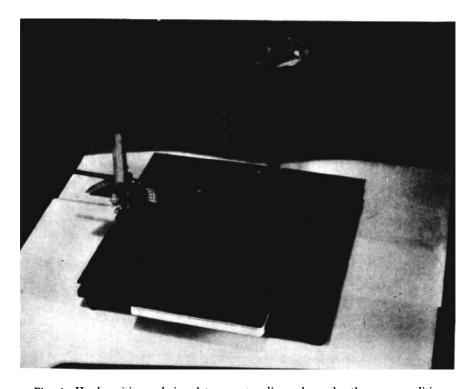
Head positioner designed to repeat radiographs under the same conditions at different intervals.
